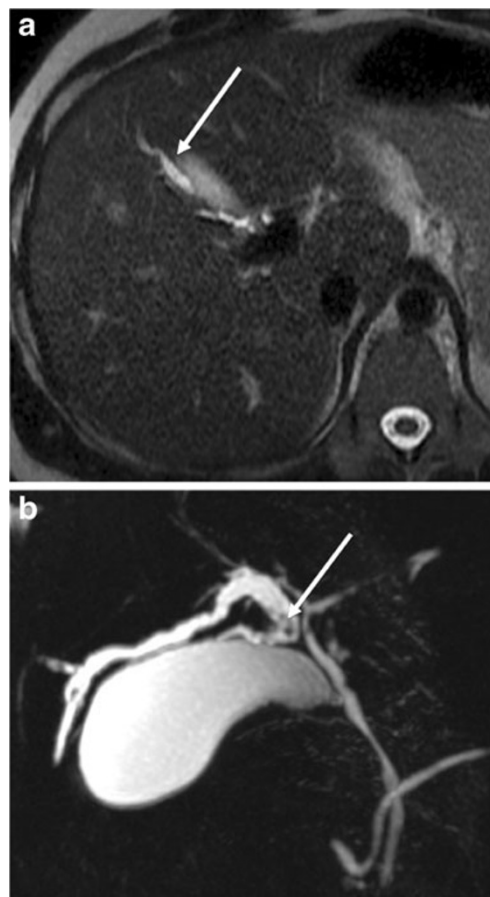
Unifocal mild biliary dilatation with biliary stone in a 40-year-old man with LPAC syndrome. The dilatation is located in the segment V on T2-weighted acquisitions (white arrow in a) and 3D MRCP (b) and contains a small signal void corresponding to an endoluminal stone (white arrow in b). The gallbladder and the common bile duct show no abnormalities
